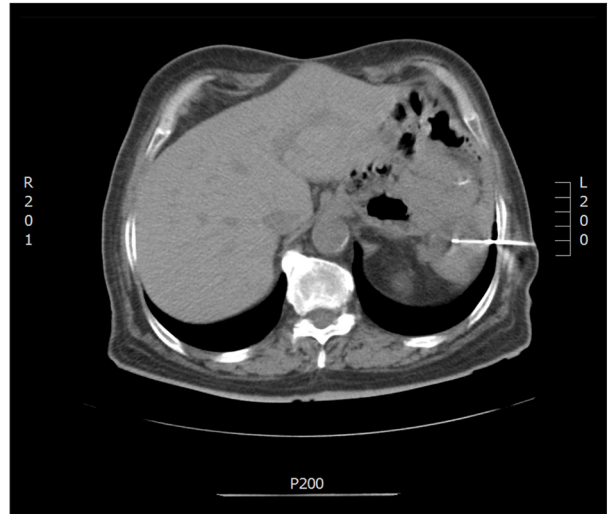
CT-guided biopsy of the recurrent tumor, albeit the patient underwent radical surgical excision and adjuvant chemotherapy.
